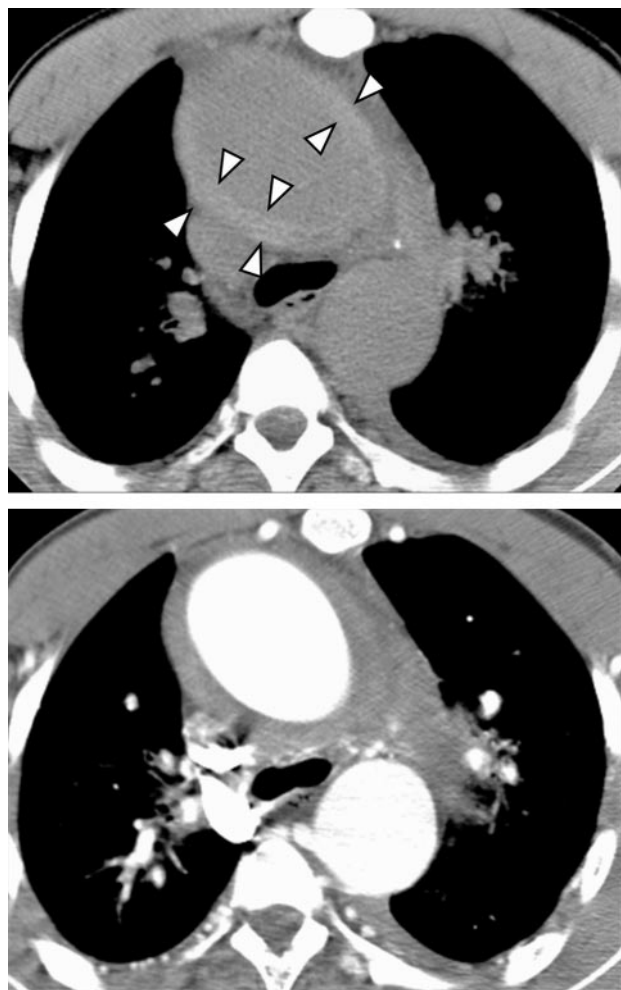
Axial CT images demonstrating the value of noncontrast images. Top, Precontrast image demonstrates a high-attenuation aortic hematoma indicating an acute aortic event. Bottom, Images obtained with intravenous contrast material demonstrate the contrast-filled aortic lumen and the hematoma as a relatively lower attenuation band. CT indicates computed tomographic imaging.
